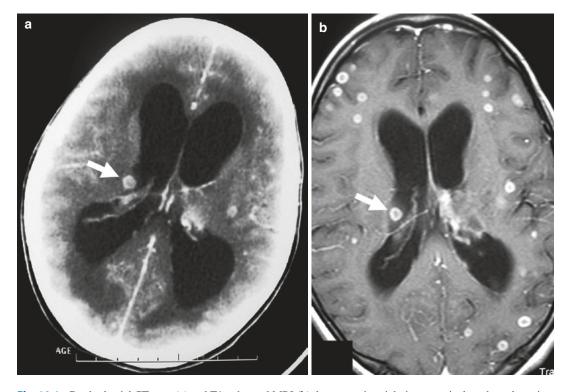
Cerebral axial CT scan (a) and T1-enhanced MRI (b) demonstrating right intraventricular tuberculoma in a context of multiple cerebral tuberculomas (Courtesy of Ali Akhaddar M.D.)
